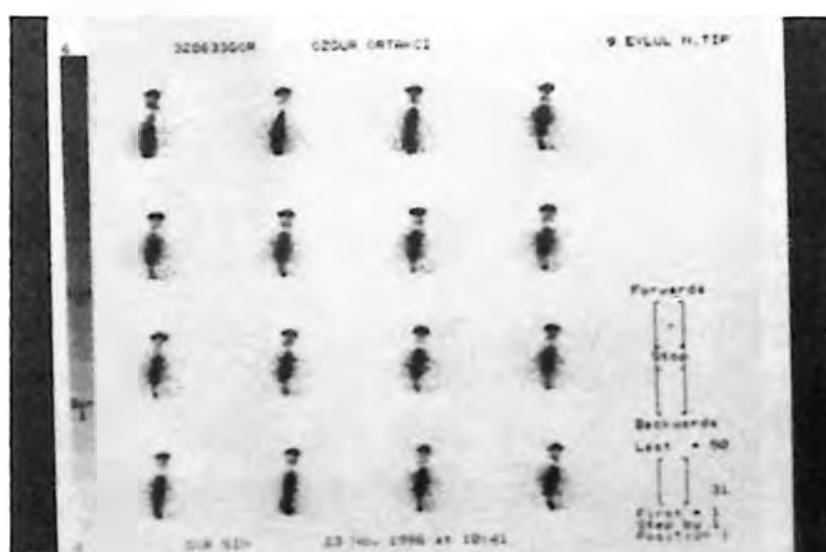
There is a marked delay in esophageal movements and reflux in series taken during scintigraphy.
